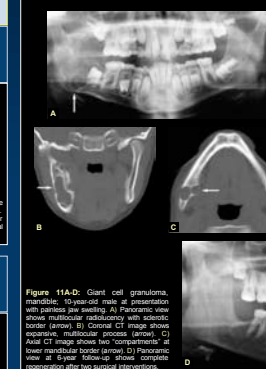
Giant cell granuloma, mandible: 10-year-old male at presentation shows multilocular radiolucency with sclerotic border (arrow). A: Axial CT image shows extensive radiolucency, multilocular masses (arrow). B: Axial CT image shows low intermediate signal (arrow) in lower mandibular border (arrow). C: Panoramic view shows radiolucency in lower mandibular border (arrow). D: Panoramic view shows radiolucency in lower mandibular border (arrow).
